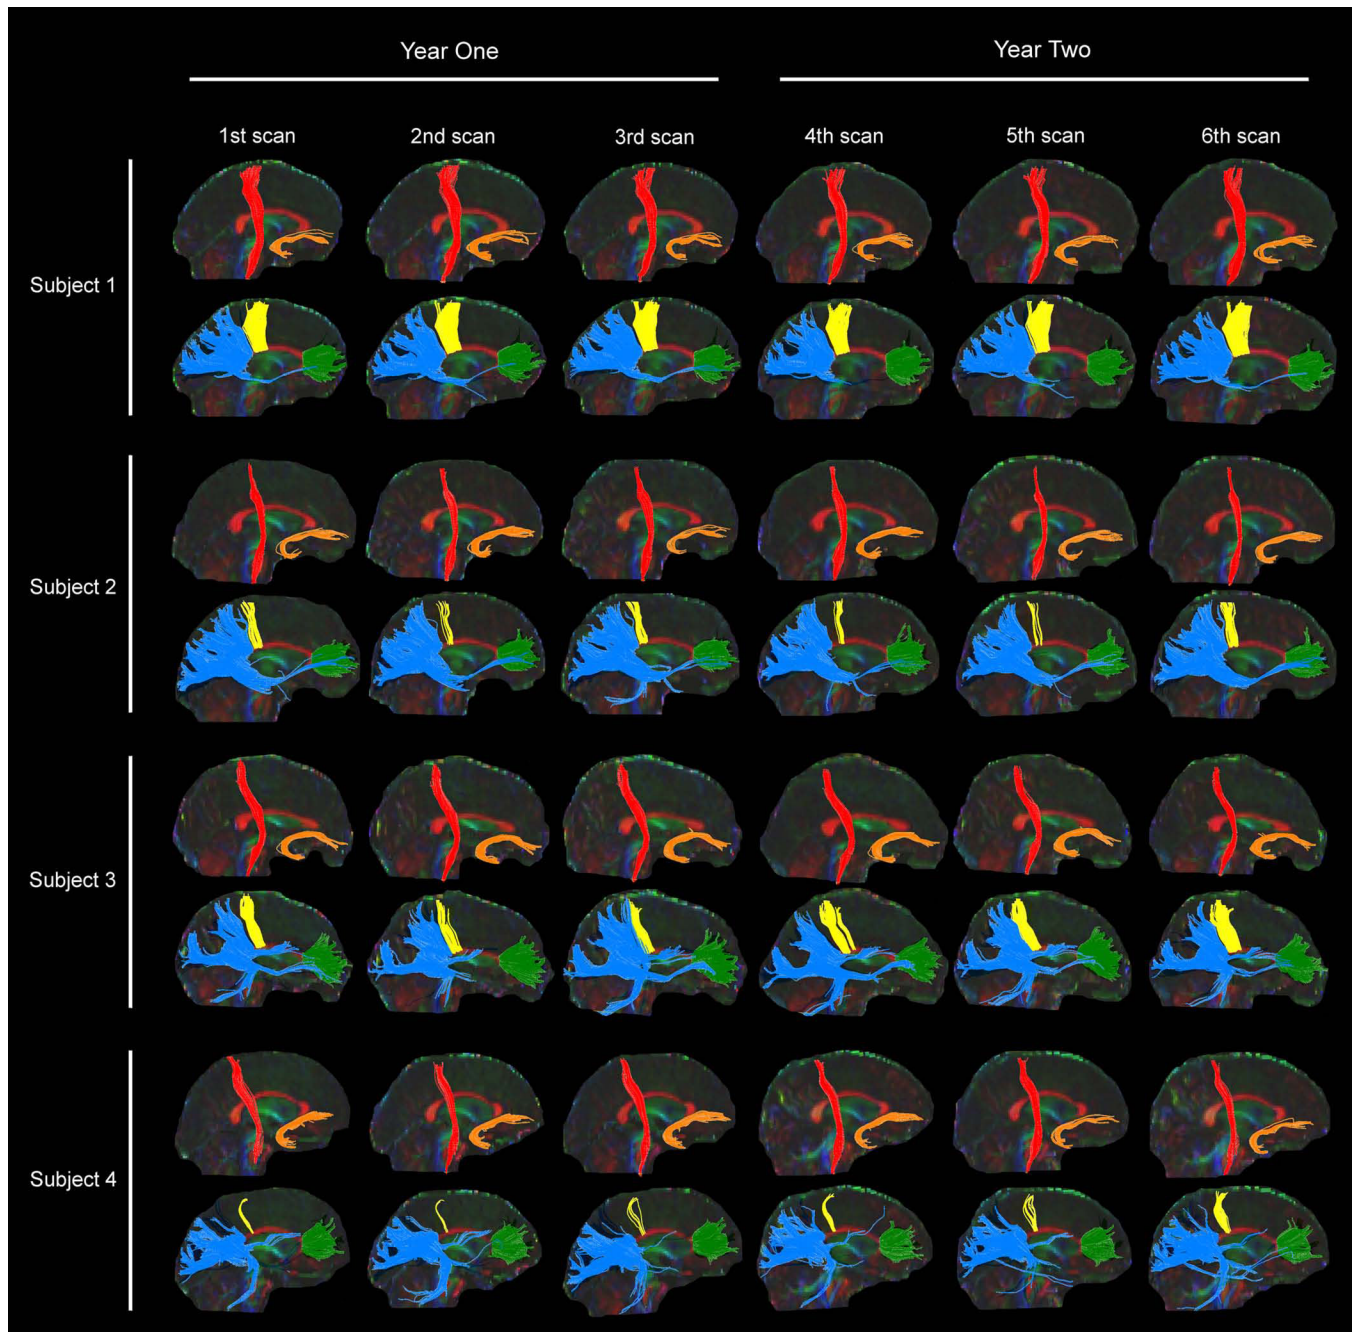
Fiber tracking results from each of the four subjects that underwent six repeat MRI scans. Right side corticospinal tract (CST) is red, right side uncinata fasciculus (UNC) is orange, genu (GE) is green, corpus callosum motor fibers (CCM) is yellow, and splenium (SP) is blue.
